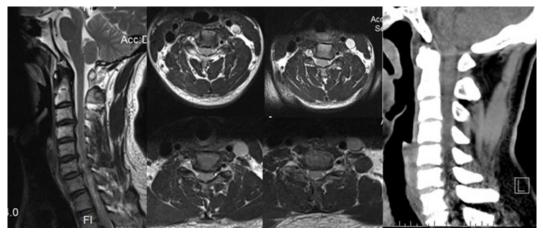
MRI and CT showed multi-segment cervical disc herniation, cervical spinal stenosis, and no obvious posterior longitudinal ligament calcification.
